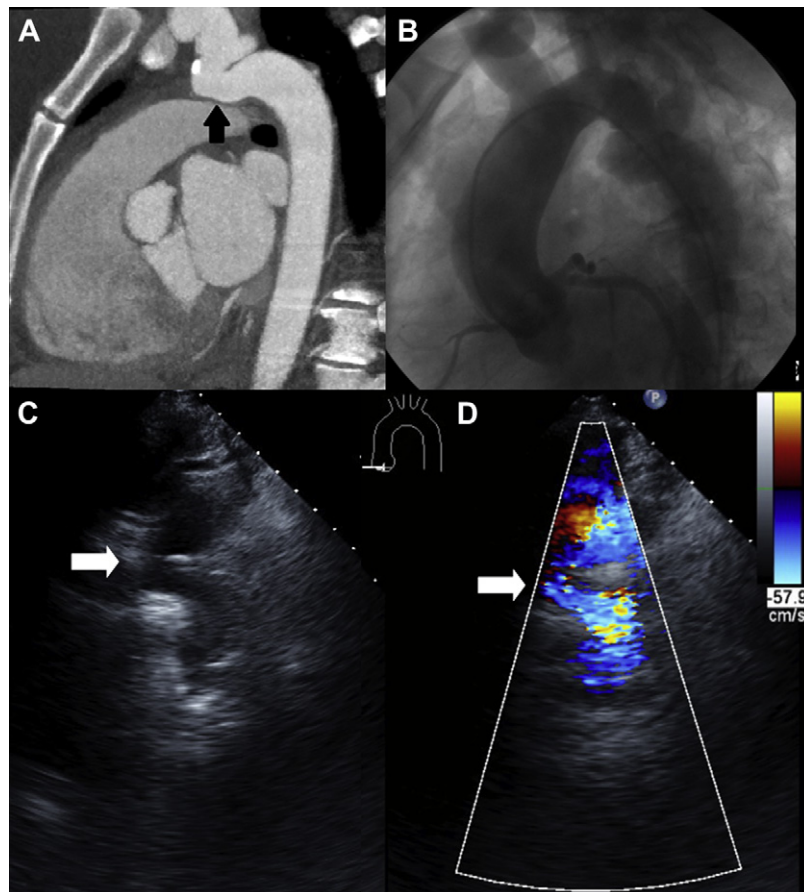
(A) Shown is 5-mm maximum intensity projections (MIP) multiplanar reformat of the aortic arch. The cervical aortic arch extended superior to the manubrium, and a luminal reduction is associated with a tortuous segment and calcification of the distal aortic arch (arrow). (B) Invasive aortogram shows the same image as panel A. (C) Transthoracic image of the coarctation (white arrow). (D) Transthoracic image of the coarctation with color Doppler (white arrow).
